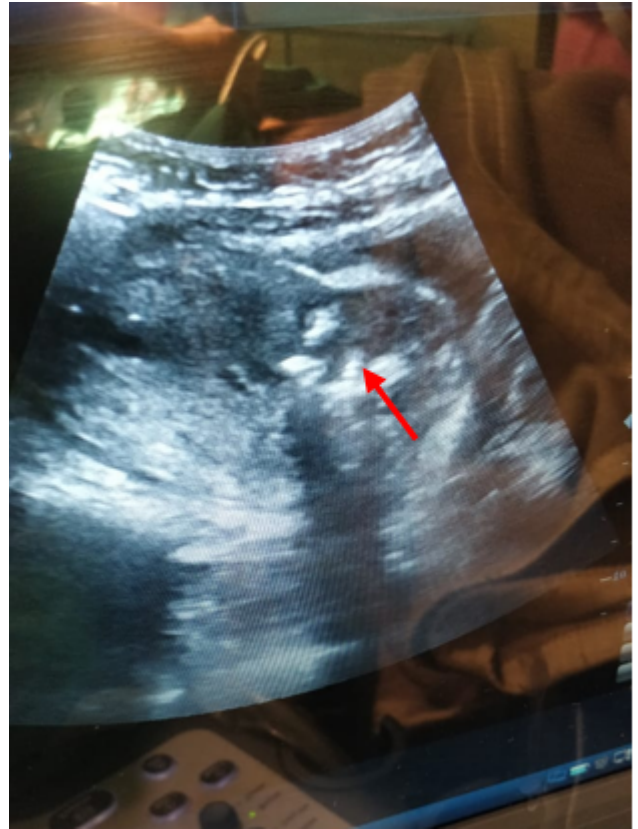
Trans-abdominal Ultrasound showing multiple echogenic areas in the lower part of uterine musculature
